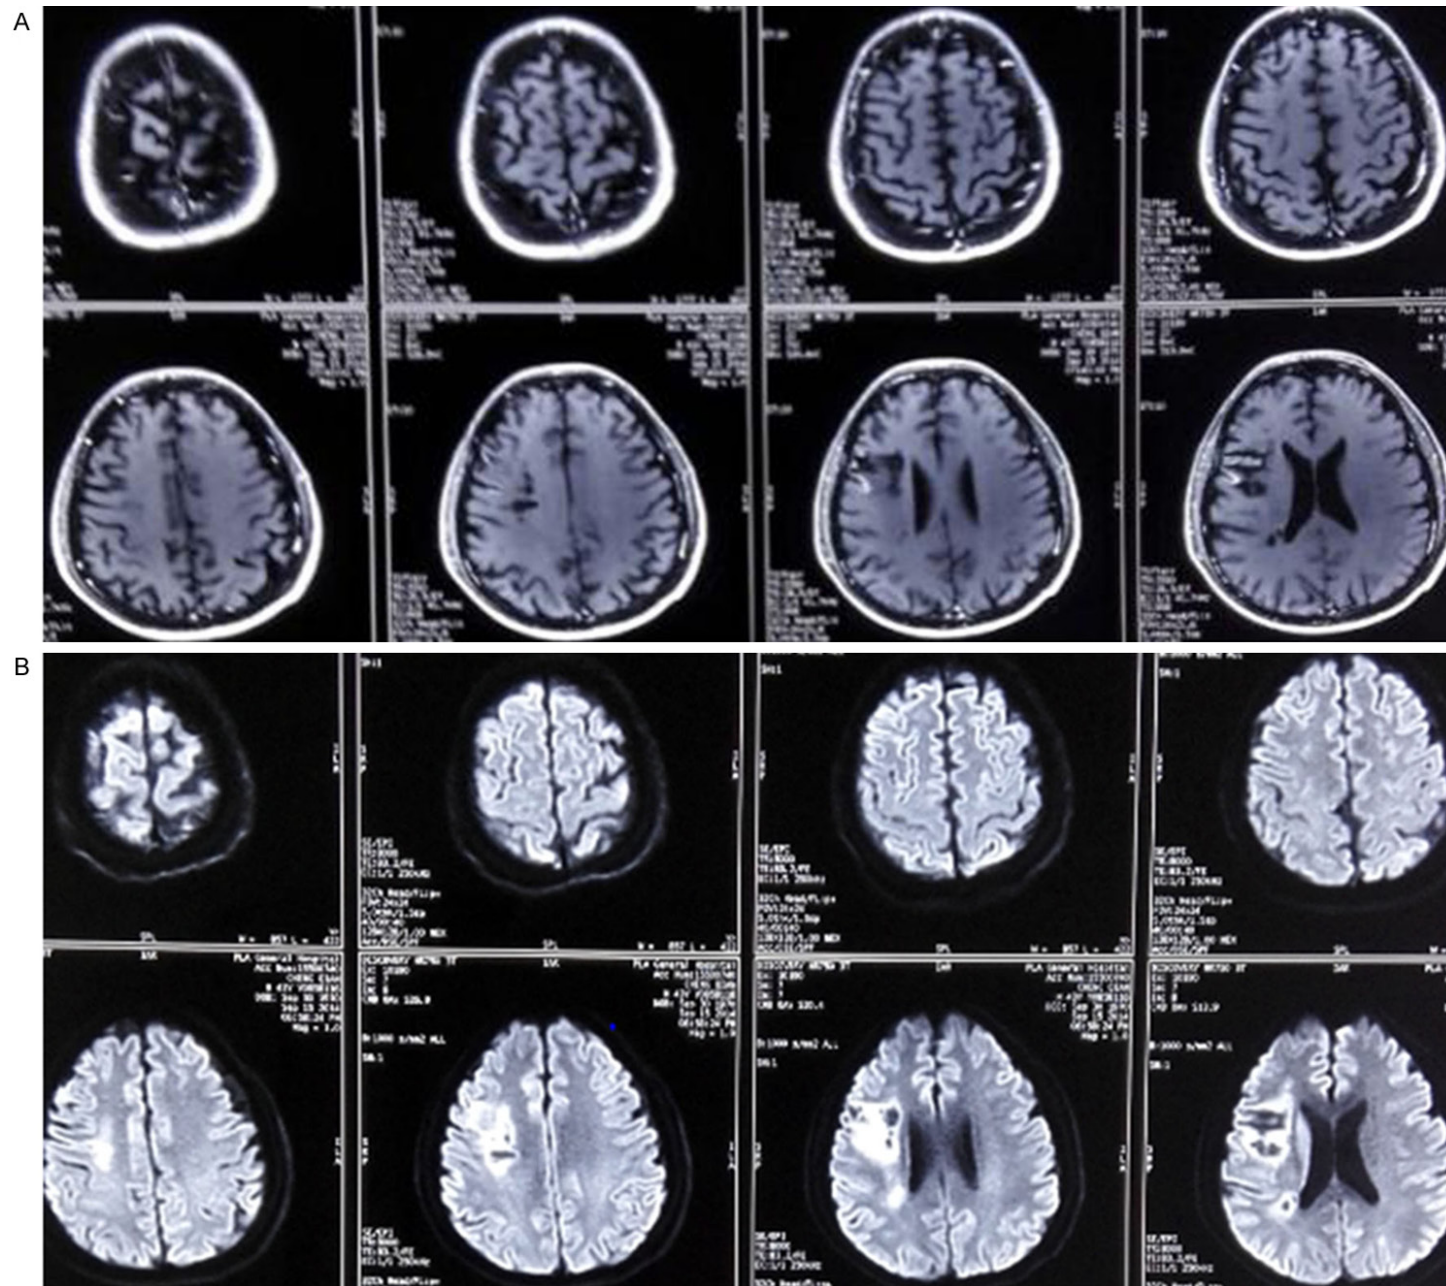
Cerebral MRI examination (A. T1; B. DWI).
